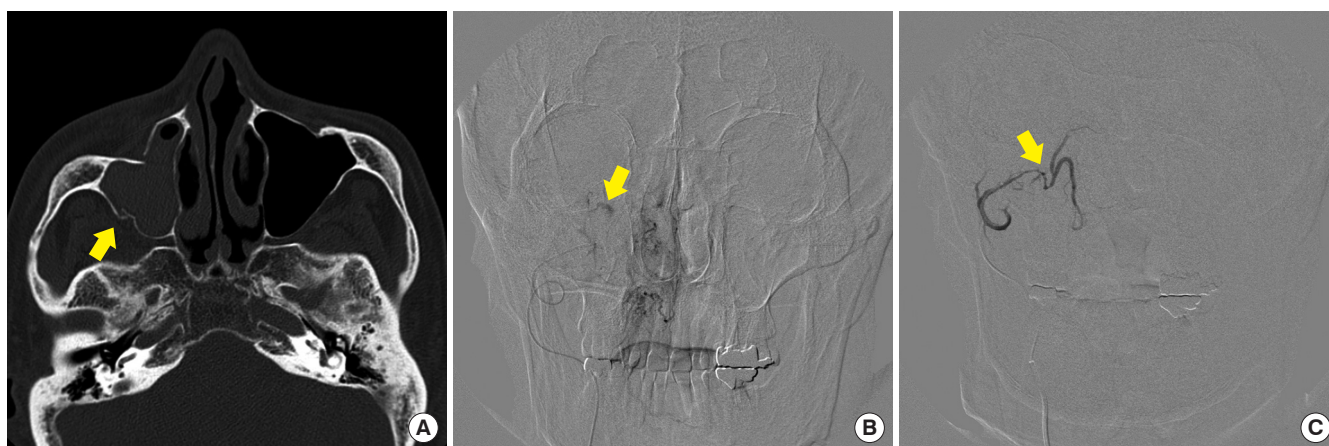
(A) Preoperative computed tomography scan of the facial bone in a 60-year-old male (patient 2) presenting with right zygomaticomaxillary complex fracture (arrow) following blunt trauma. (B) Angiography of patient 2 revealing pseudoaneurysm and extravasation of left sphenopalatine artery (arrow). (C) Angiography of patient 2 after endovascular embolization of sphenopalatine artery with gelatin sponge (arrow). Embolization was successfully done without recurrent bleeding episode after the procedure.
